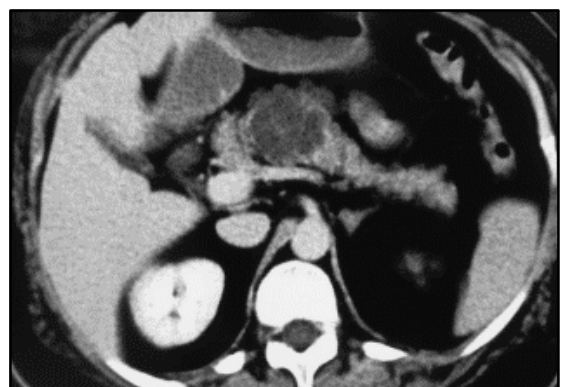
Serous Cystadenoma- Axial Contrast-Enhanced CT Image Shows a Microcystic Lesion with Central Scar in the Region of Pancreatic Body.
